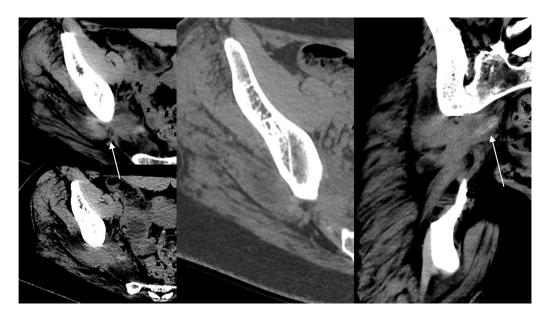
Axial and Coronal CT demonstrating a heterogeneous mass-like density involving the right piriformis, gluteal, and quadratus femoris musculature.
